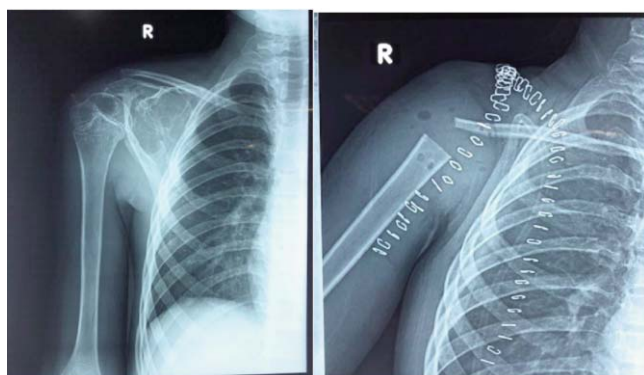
Image of a young boy with tumour involving scapula, shoulder joint and proximal humerus with post-operative X-ray showing Tikhoff Linberg type resection and reconstruction.
